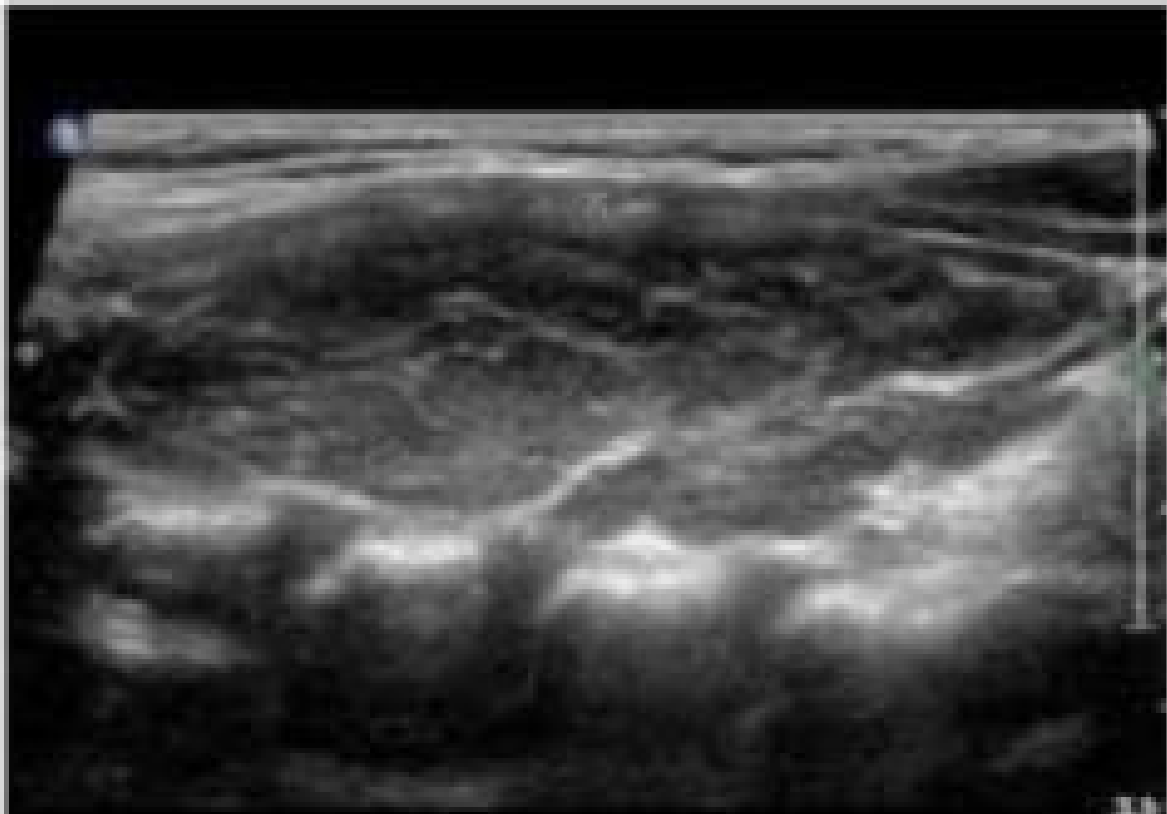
Ultrasound examination of the of Hypothyroidism a 45-year-old woman showing non homogeneous in texture
